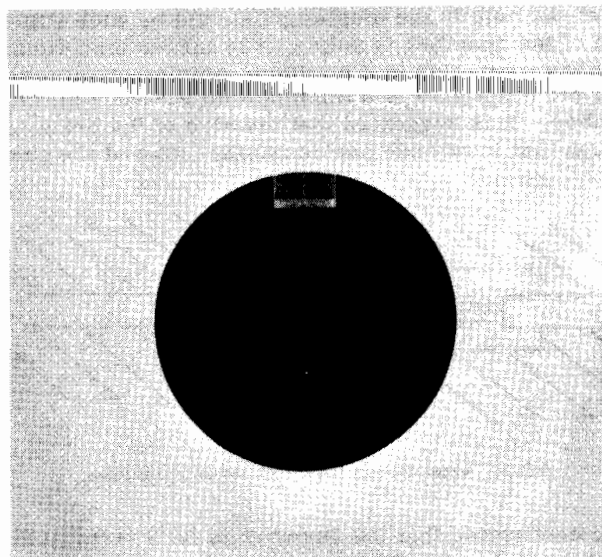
Radiograph of ionization chamber in beam.
